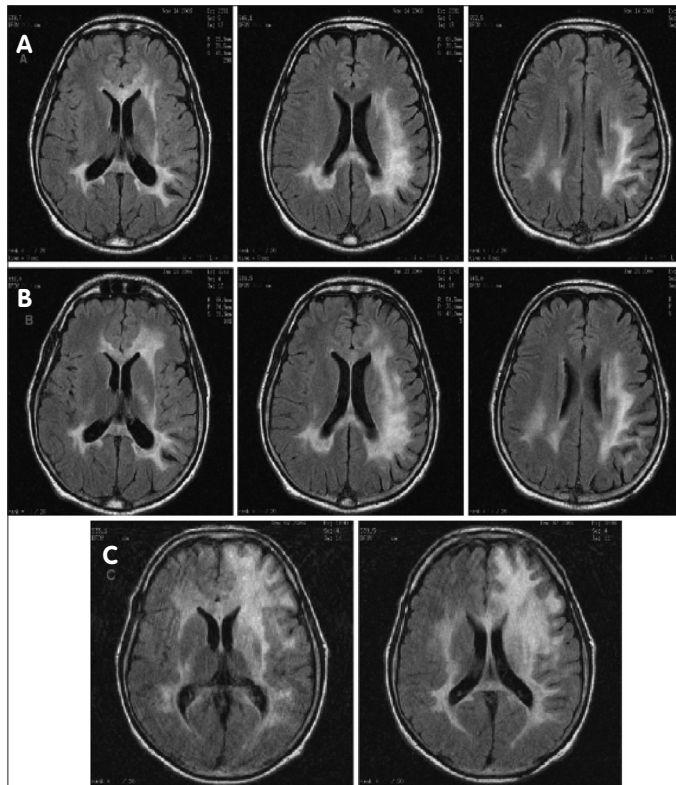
A. Transverse FLAIR MRI series (progression of white-matter hyperintensity within one year) showed incipient demyelination predominantly in the left hemisphere with relative sparing of the U fibers. B. 6 months later. C. 12 months later confluent hyperintensive lesion representing severe demyelination including the U fibers
